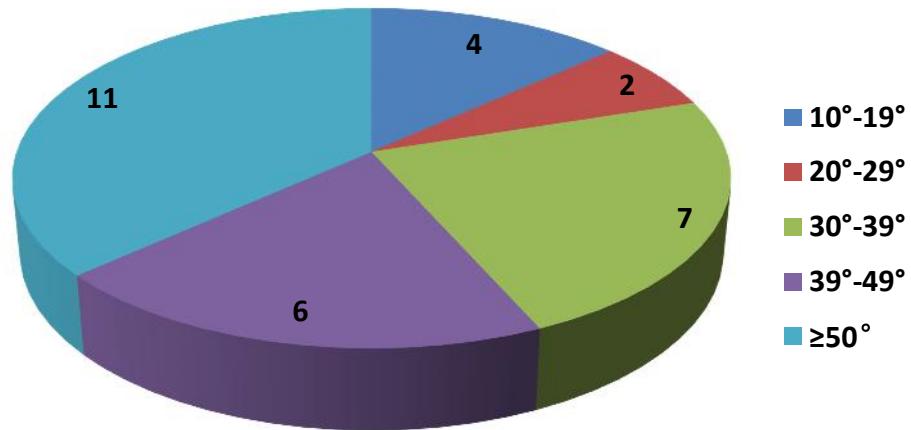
Radiographic Parameters of the Cobb Angles of the 30 Subjects
